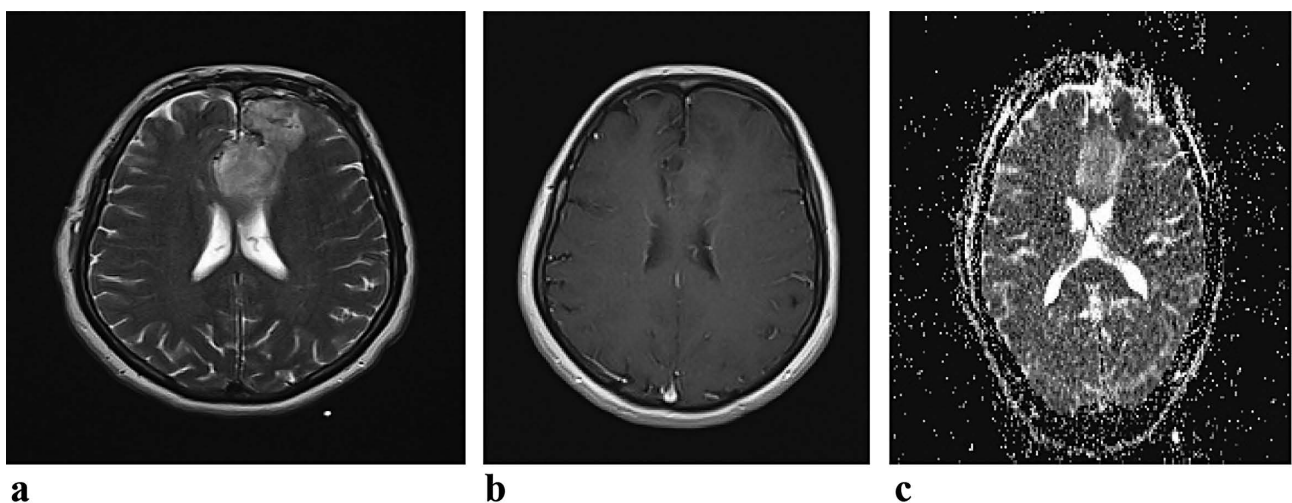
Oligodendroglioma grade II in 46-year-old woman. Transverse (a) preoperative T2-weighted MR image (3600/96), (b) contrast-enhanced T1-weighted MR image (440/14), and (c) ADC map show irregularly shaped enhancing tumor (arrows in a) with perifocal edema in left mediofrontal lobe. Minimum ADC value was $1.257 \times 10^{-3} \text{ mm}^2 \cdot \text{sec}^{-1}$.
